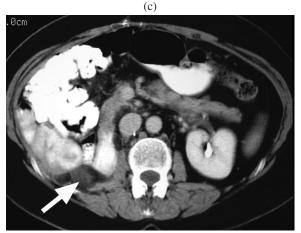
Recurrent liposarcoma. (a) Contrastenhanced axial CT shows right retroperitoneal mass (arrow) which as a liposarcoma. (b) On a 6-month post-resection follow-up contrast-enhanced axial CT, there is suggestion of recurrence (arrow). This was interpreted as being indeterminate for recurrence. (c) At 12-month follow-up contrast-enhanced axial CT, the mass (arrow) has shown interval growth and is more obvious. This proved to be recurrent liposarcoma.
